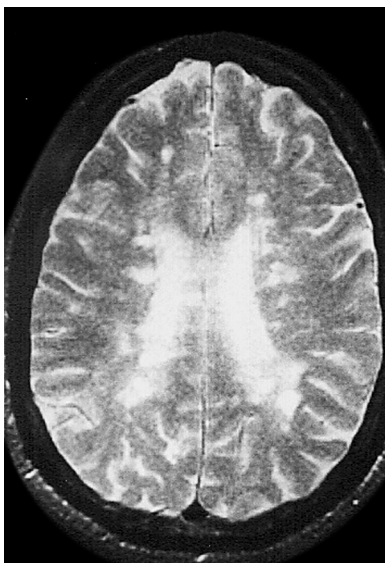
Abnormal MRI in a patient with multiple sclerosis. Classic periventricular white matter lesions appear bright on T2-weighted image.
